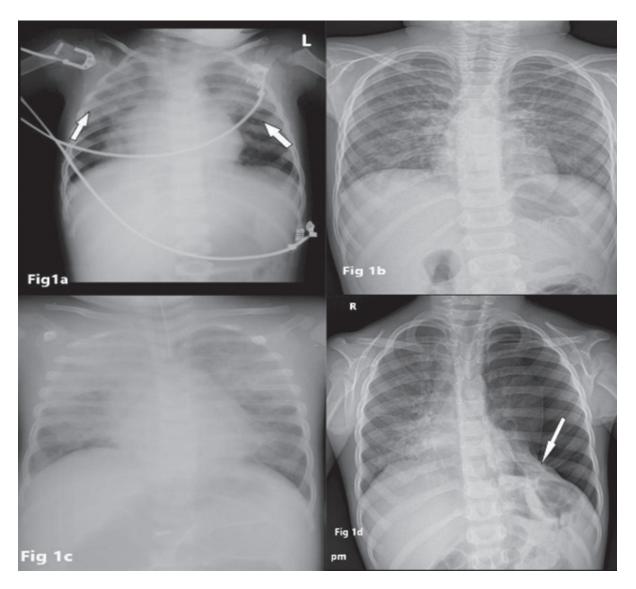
Chest x-ray showing 1a. Bilateral patchy consolidation of upper and middle zone (white arrow). 1b. Bilateral peribronchial interstitial shadowing. 1c. Bilateral diffuse air space opacities with hyperinflation. 1d. Left sided tension pneumothorax with mediastinal shift and collapsed border of left lung (arrow); patchy consolidation in lower lobe of right lung.
